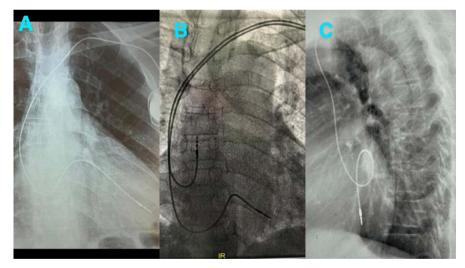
Our Patient's Chest X-ray: posteroanterior (A) and lateral (C) views indicating the pathway of the lead in the two projections. (A) The ventricular lead is positioned higher in the postoanterior view (A) than the standard position in Right ventricle of a patient without lead malposition (B); (C) Malpositioned LV lead is characteristically steered toward the spine and appear posterior, close to the spine.
